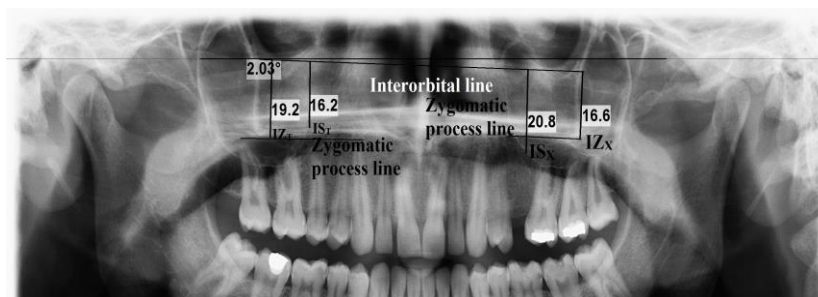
Panoramic radiograph showing the reference lines and all measurements that done
